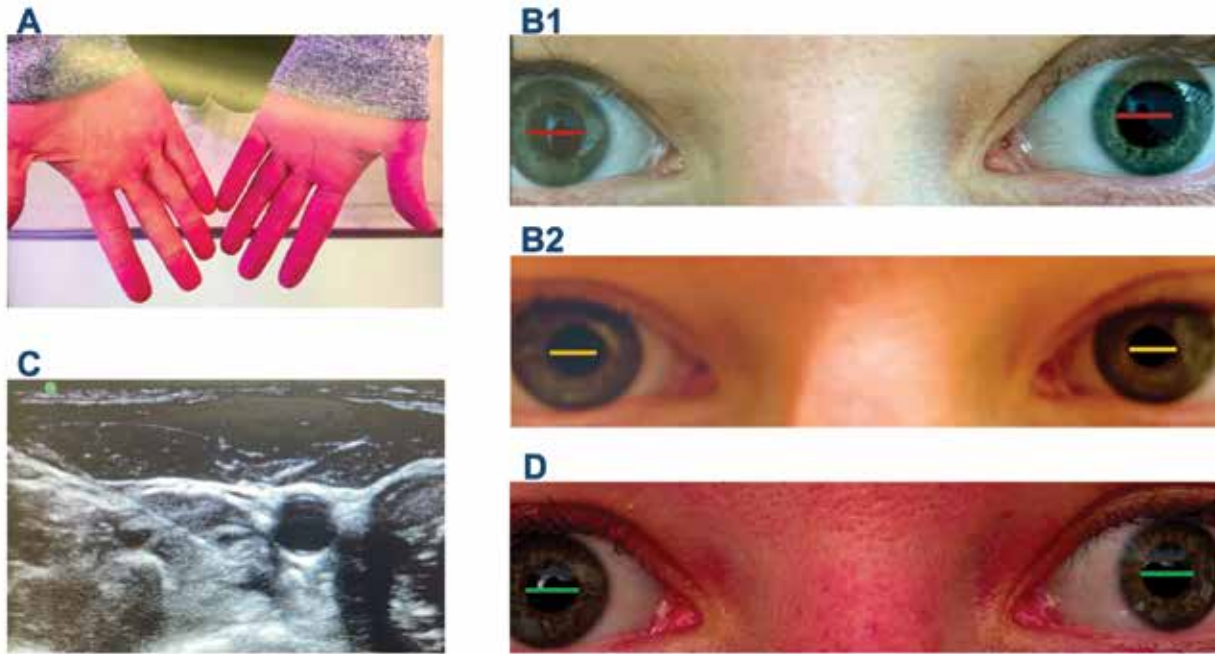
A: Patient developed complex regional pain syndrome (CRPS) type 1 after surgical decompression and C6-7-disc arthroplasty. Note discoloration of left hand; B1/B2: Fluctuating anisocoria of left eye; C: Ultrasound-guided left stellate ganglion block (SGB); D: Vision and anisocoria significantly improved after SGB. Red, yellow, and green bars are the same length.
